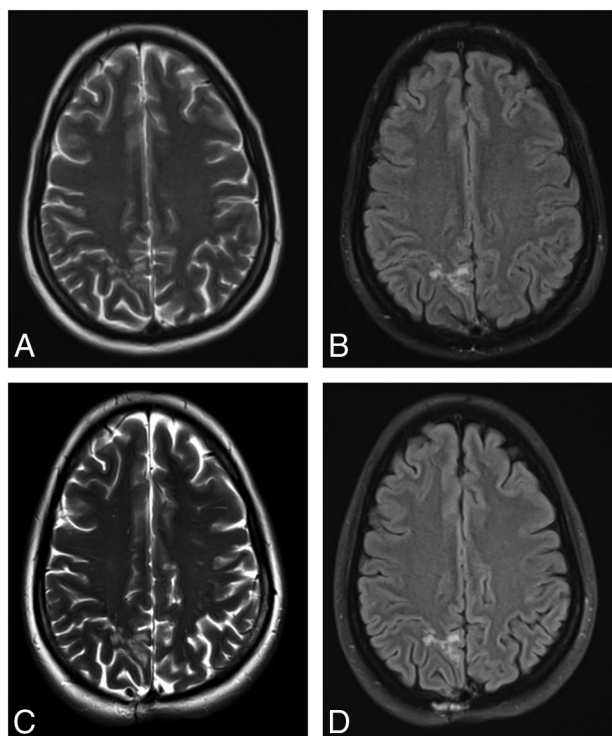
T2-weighted and FLAIR images from the baseline (A and B) and 6.4-year follow-up (C and D) MR imaging of a representative patient with a right superior parietal lobule MVNT.
